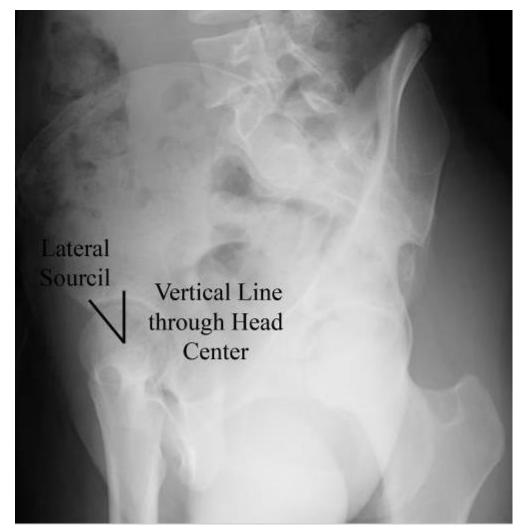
Representative technique for calculating the anterior center-edge angle on a false-profile radiograph. (JC Clohisy, A Systematic Approach to the Plain Radiographic Evaluation of the Young Adult Hip. 2008)
